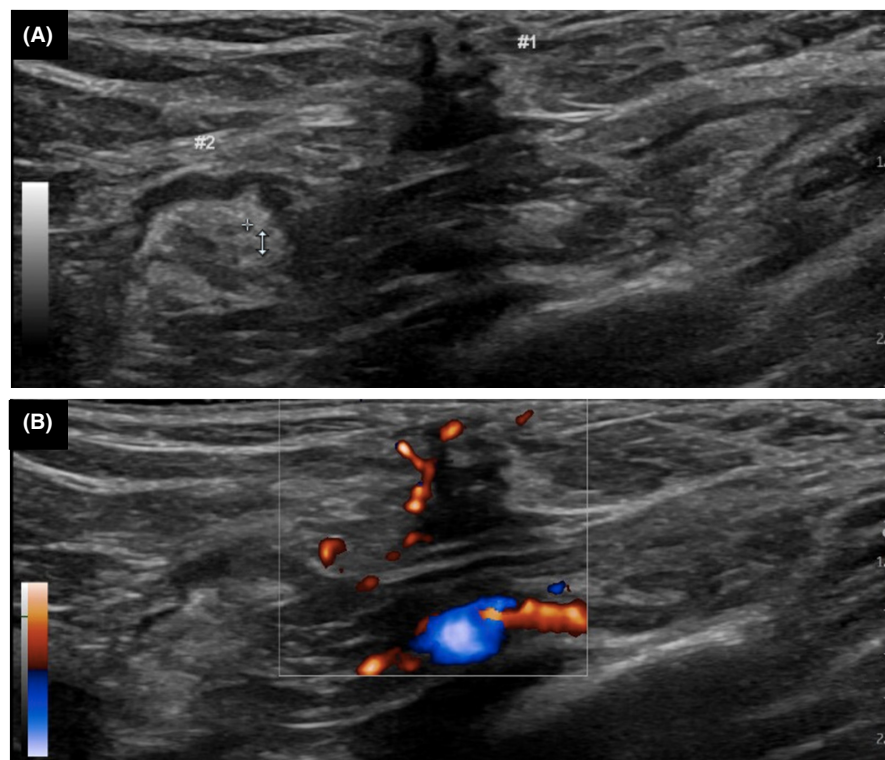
Sonographic imaging of the superior medial right axilla palpable site taken at the time of diagnostic mammography. (A) A hypoechoic irregular shaped mass (#1) and a benign-appearing lymph node (#2). (B) Representative color Doppler sonographic image of the superior medial right axilla palpable site demonstrating marked vascularity along the periphery of the mass
